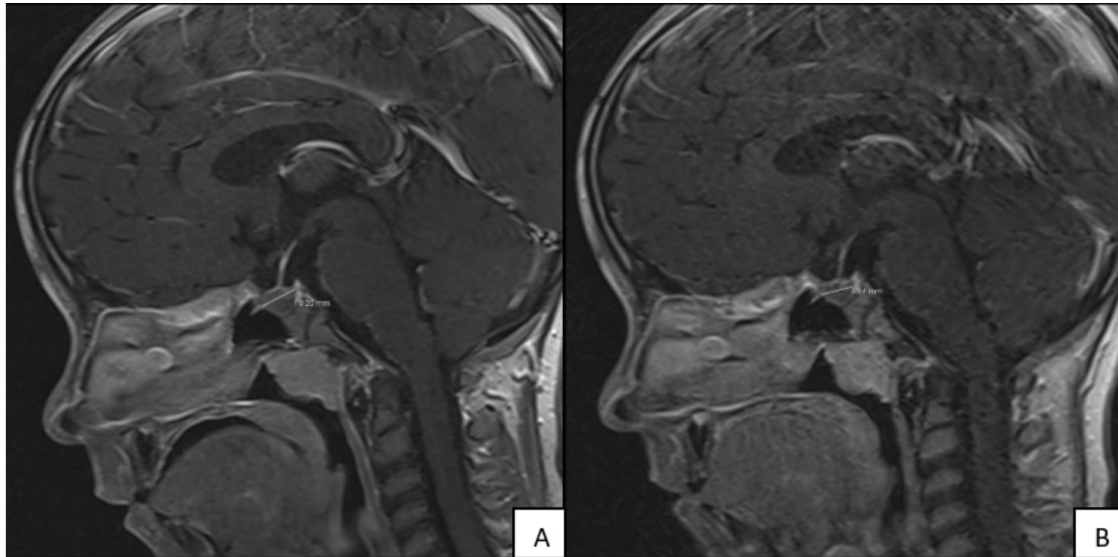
Pituitary MRI anterior-posterior image. A: before growth hormone therapy (10.2 mm), B: 1 year after growth hormone therapy (8.6 mm)
